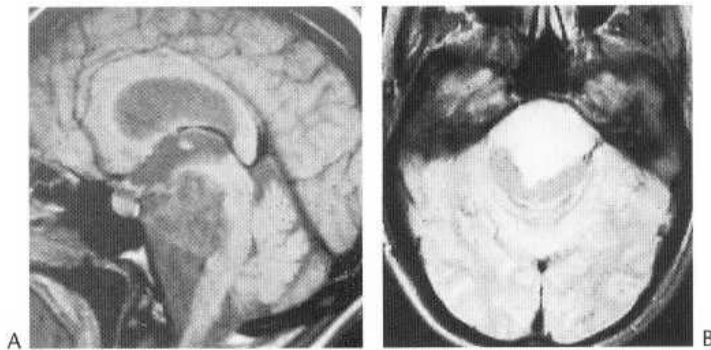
Epidermoid. (A) Sagittal MRI (T₁-weighted). An irregular tumour in the pontine cistern is displacing the pons and appears to be invading it. (B) Axial MRI (T₂-weighted). The tumour is shown as high signal displacing and compressing the central pons.
